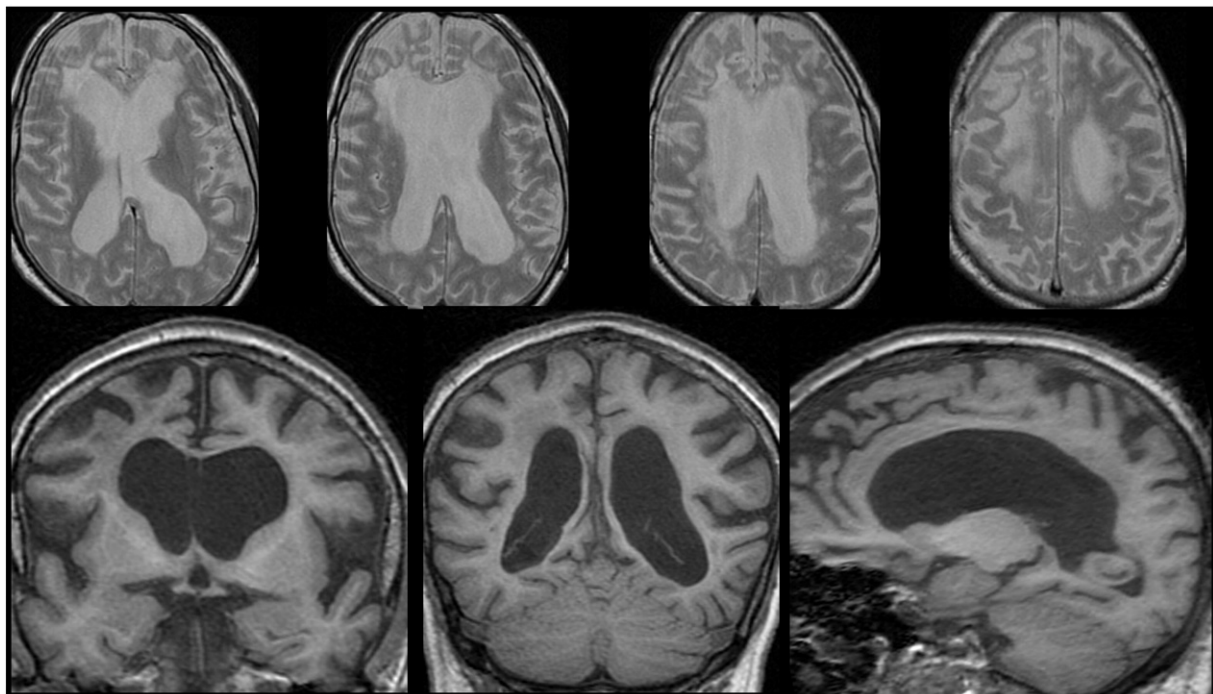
MR imaging of 1.5 showing widespread white matter change with a frontal predominance. There is associated atrophy and thinning of the corpus callosum.
